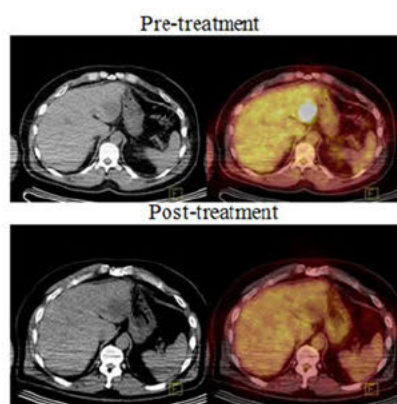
Clinical activity of ipilimumab plus bevacizumab by PET-CT (CT images on left, PET images on right). Pretreatment demonstrates an FDG avid liver metastasis. With treatment the metastasis is no longer metabolically avid but anatomically still present. With continued treatment and follow up, this lesion regressed approximately four months later without evidence of additional disease.
